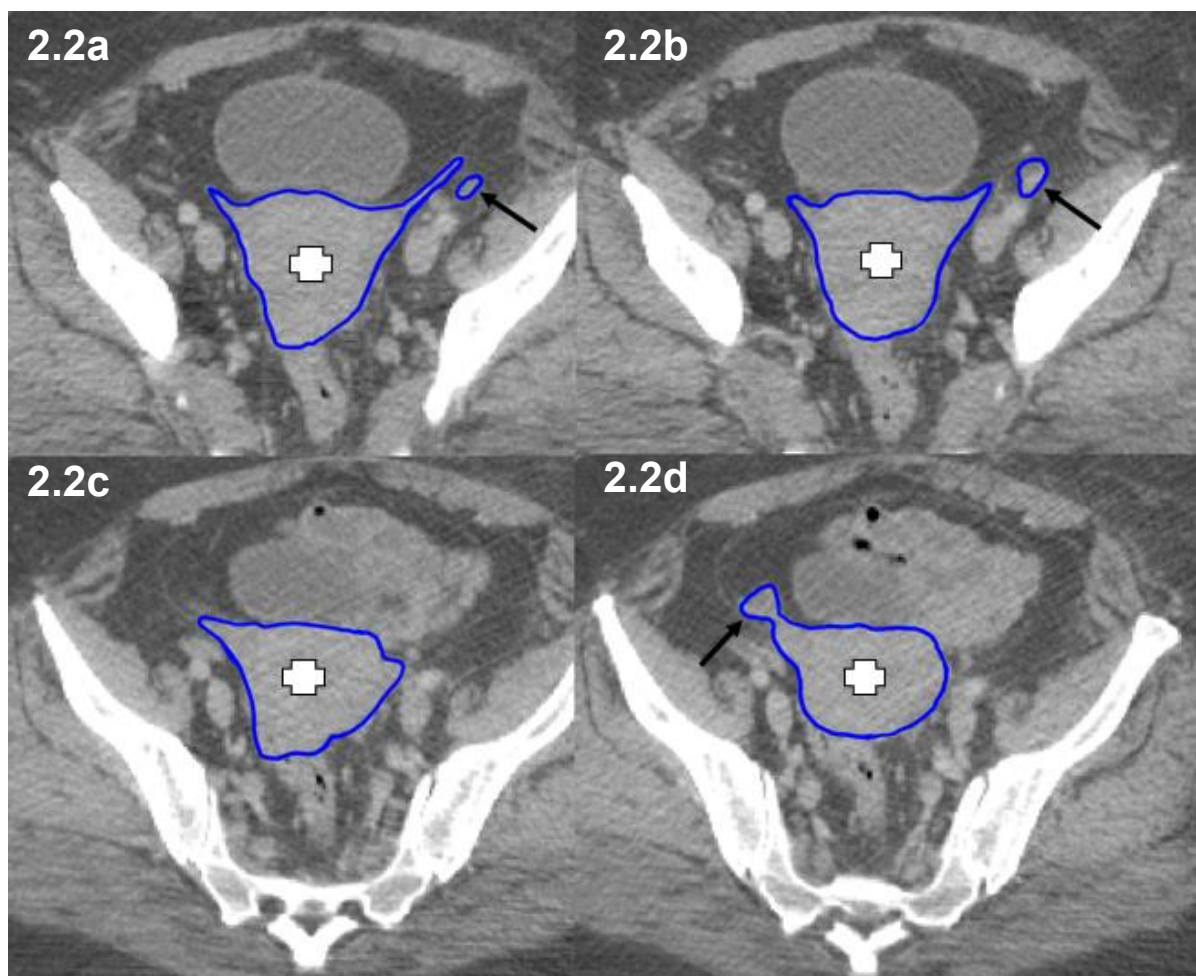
a-d: Transverse CT with uterine corpus (cross) and ovaries (arrowed, a, b and d) outlined in continuity.
